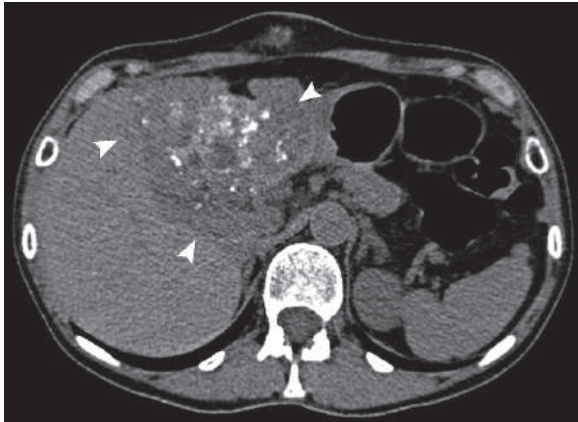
Axial nonenhanced abdominal CT in a patient with *Echinococcus alveolaris* disease affecting the left lobe of the liver shows liver mass with geographic edges (arrowheads) and internal punctuated calcifications
